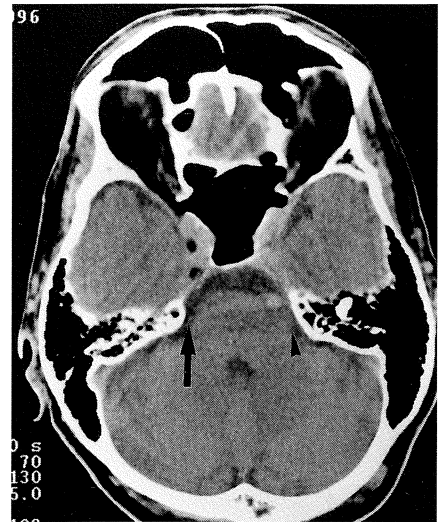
Contrast-enhanced CT scan of the same patient. The acoustic schwannoma could barely be seen as a soft tissue lesion within the left cerebellopontine angle (arrowhead). Compare this with the low attenuation CSF in the right cerebellopontine angle (arrow).
